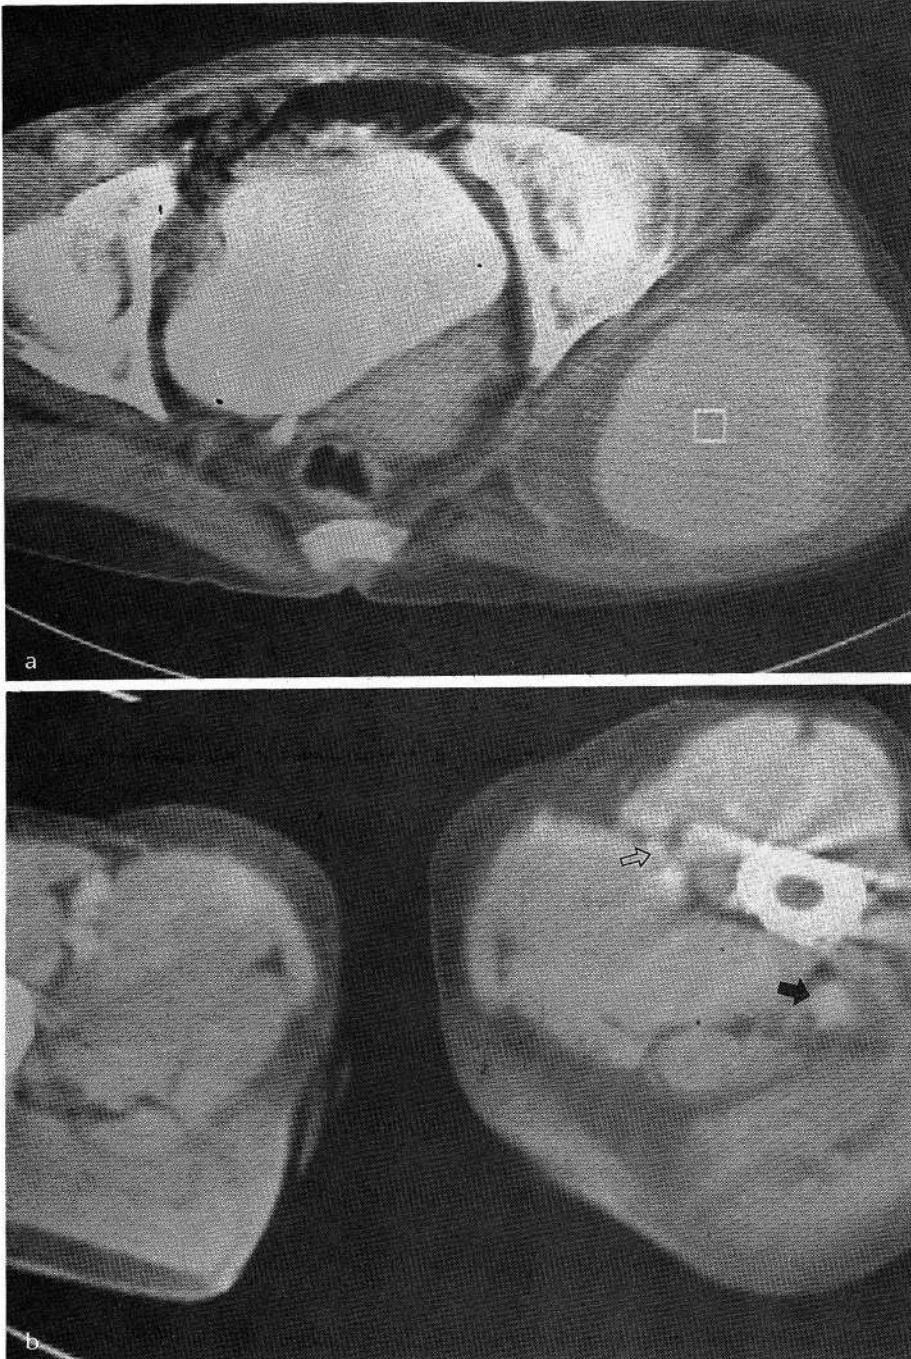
CT scan before TAE (a,b).
